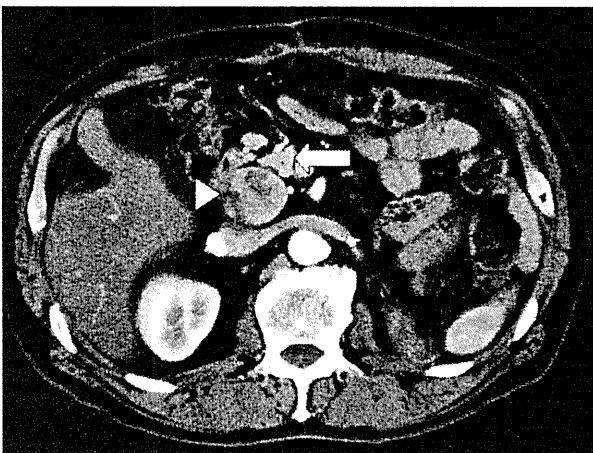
Computed tomography findings of a solitary lymph node metastasis from hepatocellular carcinoma (HCC). A round-shaped, large lymph node (*arrowhead*) was found on the posterior surface of pancreas head (*arrow*). The lymph node was 6.0 cm in diameter and showed early enhancement in the arterial phase of the dynamic study
